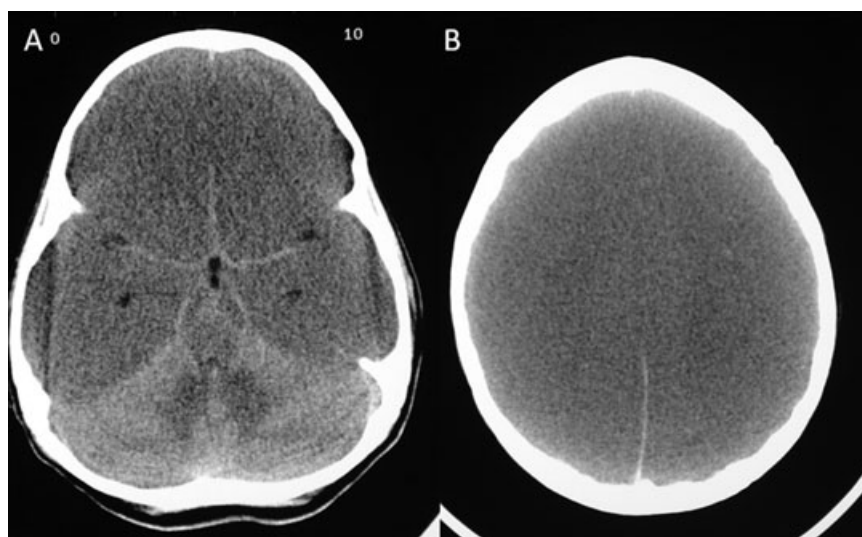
Axial CT images show the classical “white cerebellar sign” (A) in a patient with diffuse cerebral edema (B). The intact, non-ischemic/edematous cerebellum appears hyperdense relative to the edematous, hypoattenuated supratentorial brain. In addition, the cortico–medullary differentiation is obscured and the brain sulci are effaced.
